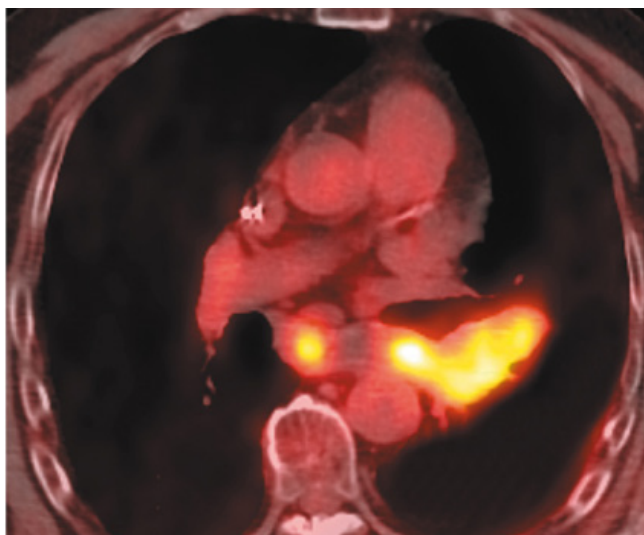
PET/CT scan of the chest. It shows intense contrast uptake at the level of the tumour lesion and also in a subcarinal adenomegaly
